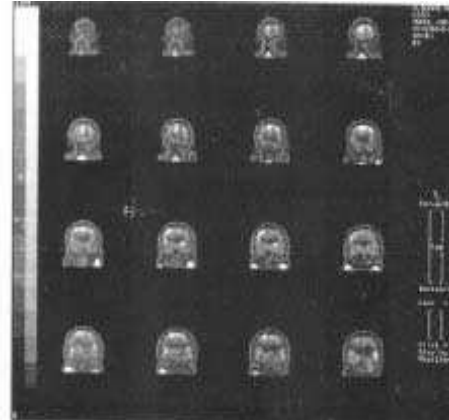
Coronal section through the cerebrum, normal cerebral SPECT scan.
